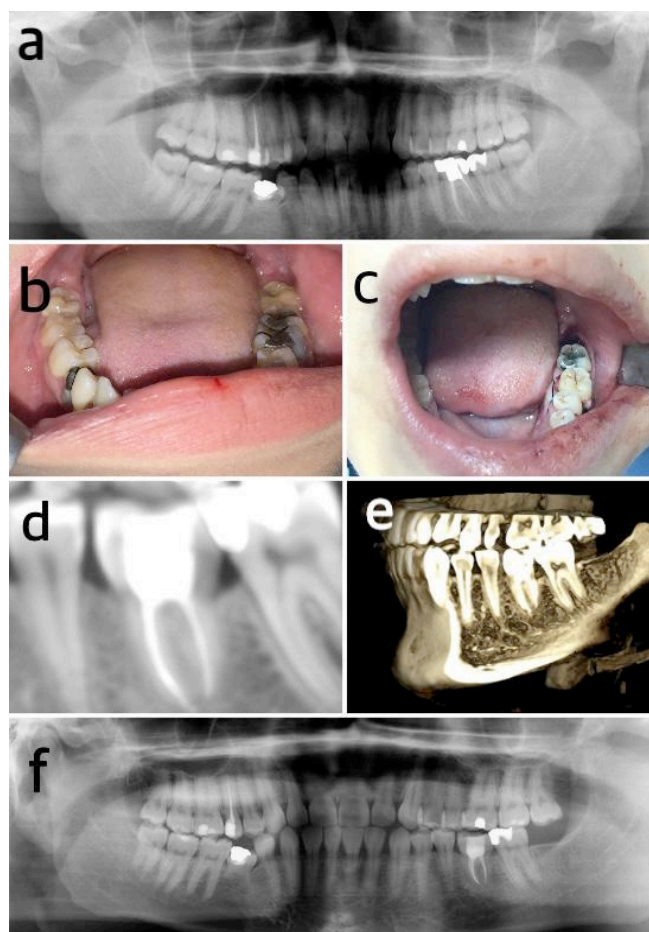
A: Patient’s pre-operative panoramic film, B: Patient’s pre-operative intraoral image, C: Patient’s post-operative intraoral image, D,E: Post-operative 2nd year CT images
